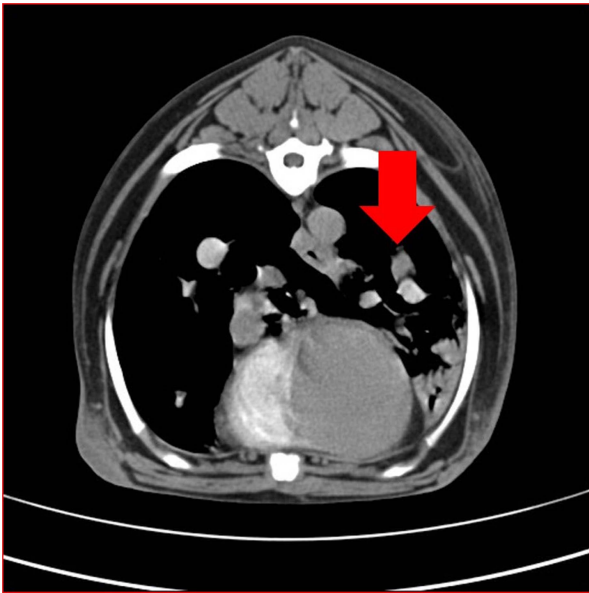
Chest spiral computed tomographic scan with a radio contrast agent showing the filling defect in the pulmonary arteries relating with pulmonary thromboembolism.
